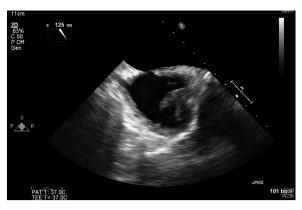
Transesophageal echocardiography showing large vegetation filled the entire lumen of the visualized portion of the superior vena cava.
